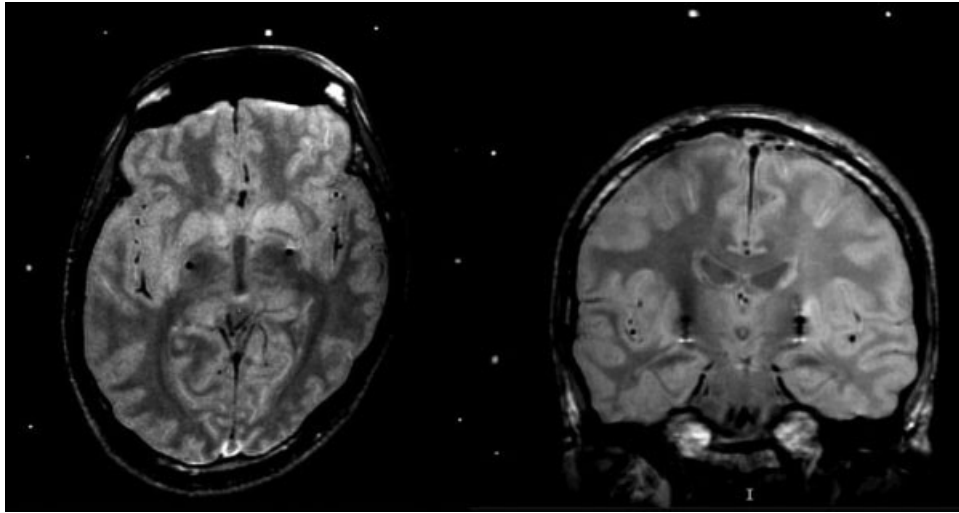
Proton density axial and coronal stereotactic MR images showing the DBS electrodes located bilaterally in the posteroventral internal globus pallidus. Note the plagioccephaly and resulting asymmetry of the basal ganglia that would have rendered indirect targeting extremely inaccurate.
